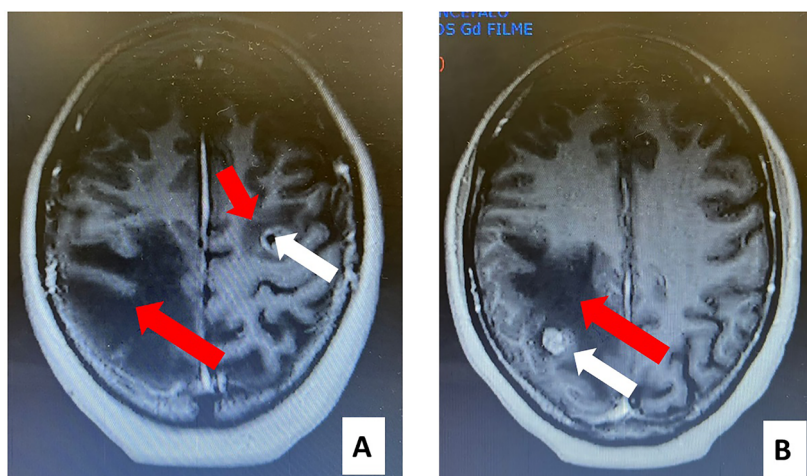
A. CT scan showing a mass at left temporal lobe (white narrow) and edema surrounding the mass and in the contralateral hemisphere (red narrows). B. CT scan showing a mass at right parieto-occipital lobe (white narrow) and edema surrounding the mass (red narrow). It is possible to visualize that the expansive effect of the mass determines regional erasure of sulcus and fissures without deviation of the centromedian structures.
